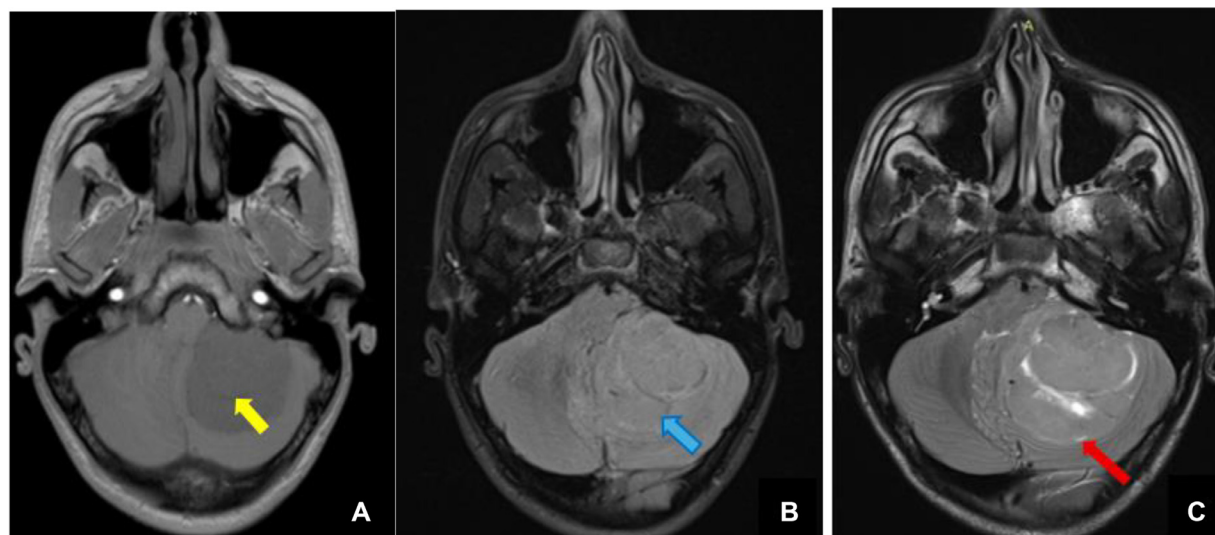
Hypo intense signal on T1 (A) (yellow arrow), iso signal on FLAIR (B) (blue arrow) and a thin layer of CSF surrounding tumor on T2 (red arrow).
